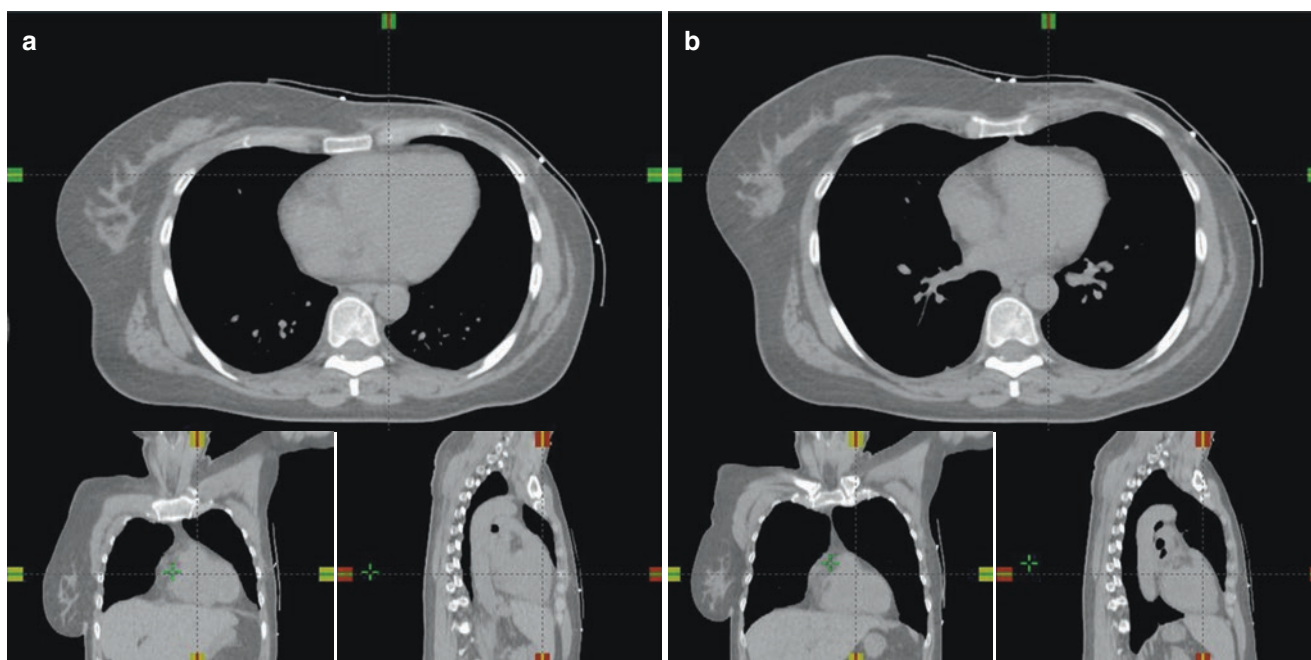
CT scan of a patient in (a) free breathing and (b) deep inspiration breath hold
